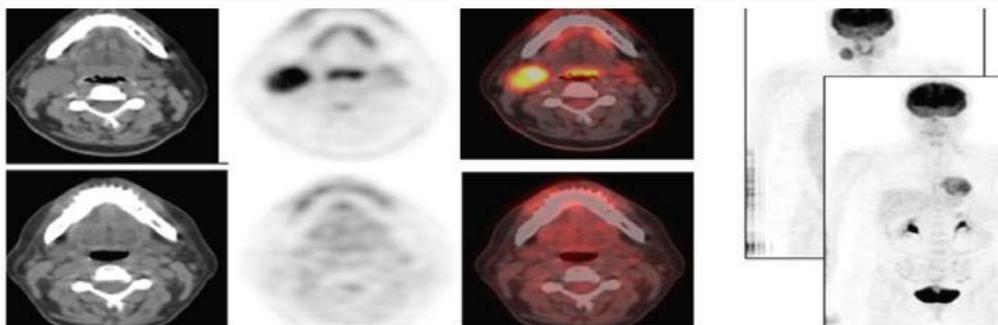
Pre- and post-treatment representative images from PET-CT scan. a) Pre-treatment scan showing uptake in the cervical lymph node. b) Post-treatment scan without the uptake in the neck. c) Pre-treatment scan showing uptake in the nasopharynx. d) Post-treatment scan without the uptake in the nasopharynx.
